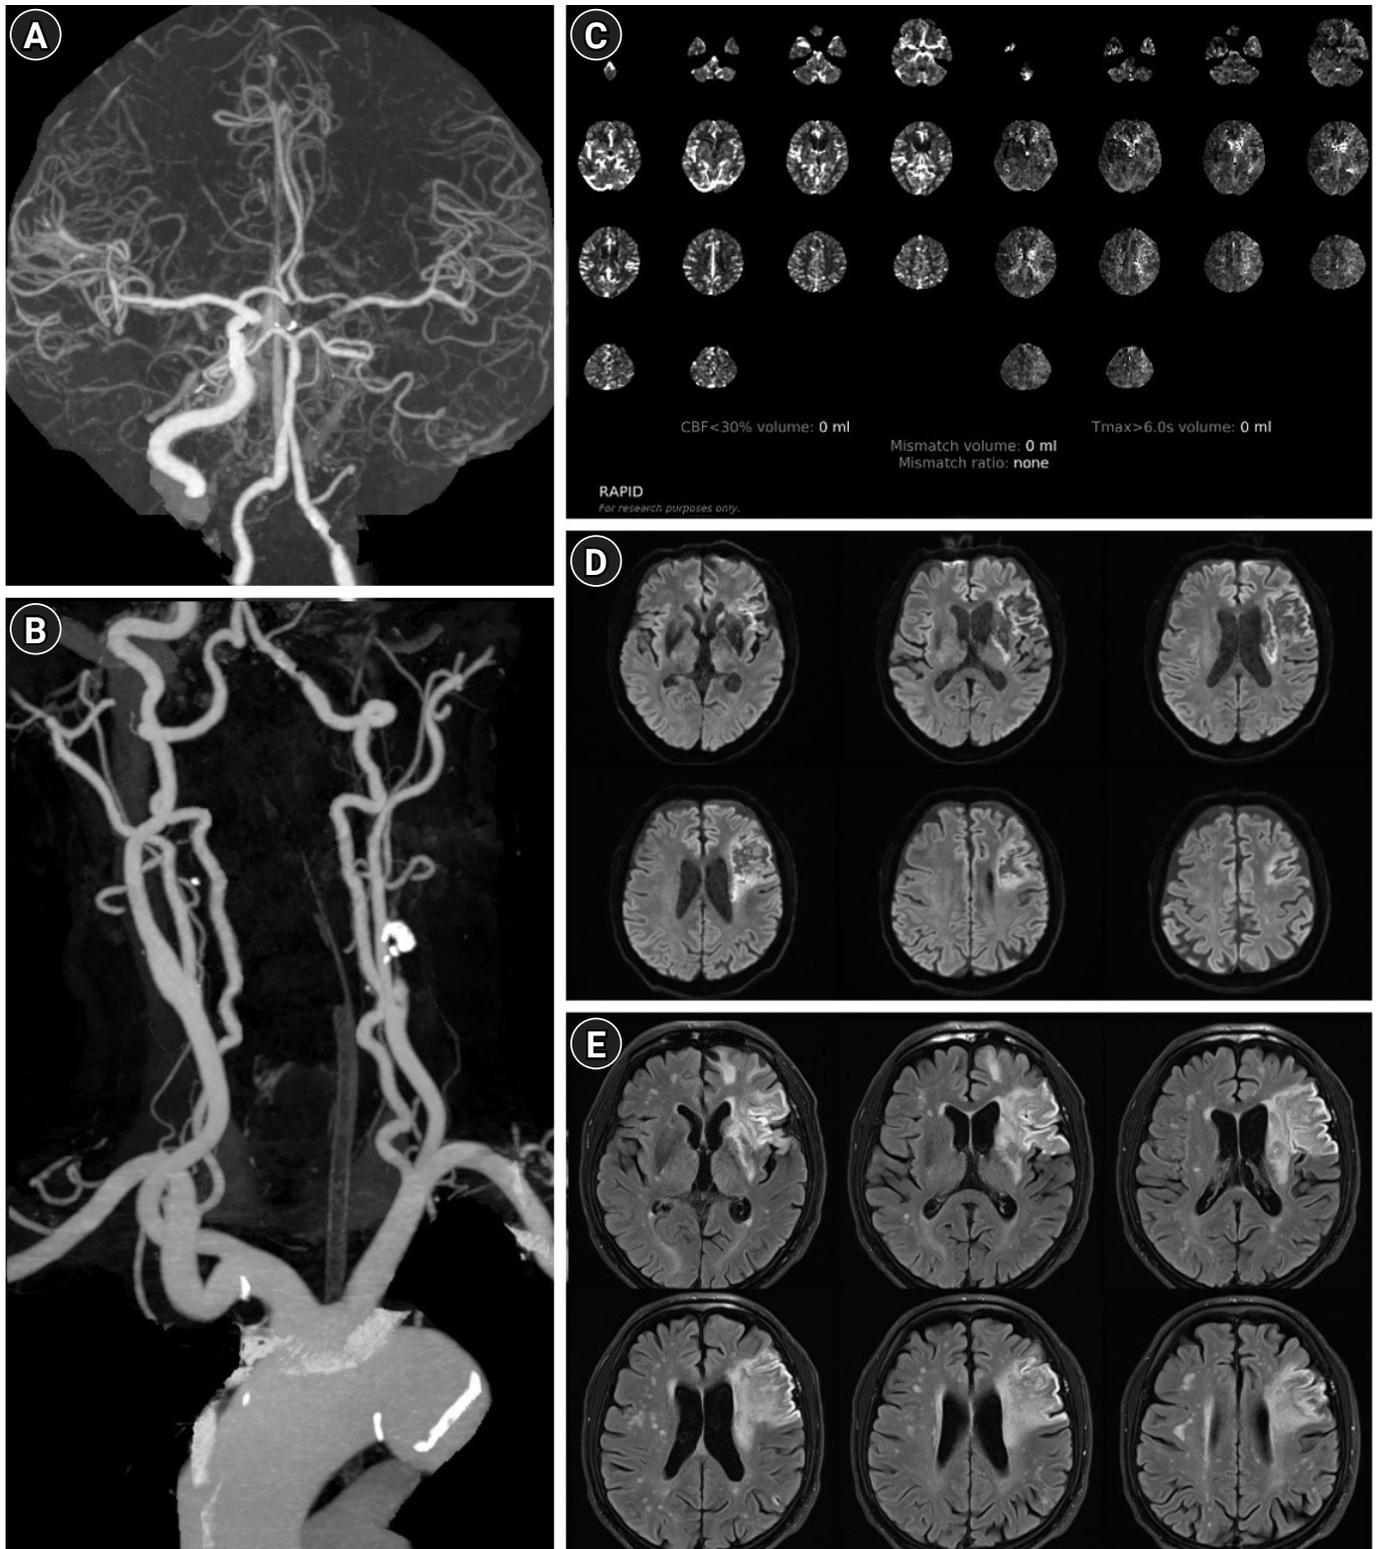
Follow-up brain perfusion computed tomography angiography (CTA) and magnetic resonance imaging were performed on day 24 after early neurologic deterioration. (A) Brain CTA showed spontaneous recanalization of the left middle cerebral artery and (B) no interval change of the internal carotid artery occlusion. (C) Perfusion mismatch was no longer observed. (D, E) No new lesions were identified on diffusion-weighted imaging or fluid-attenuated inversion recovery. CBF, cerebral blood flow.
